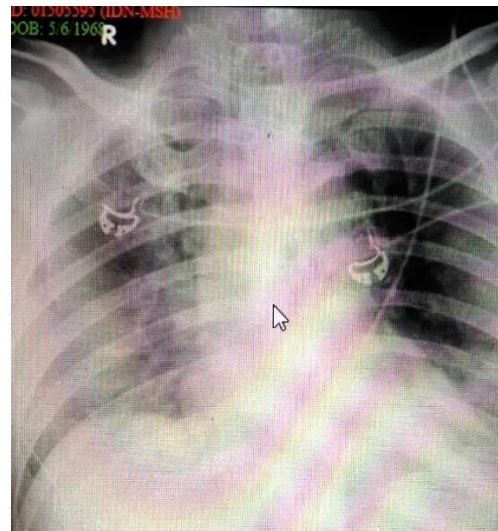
(A, B, C): Chest x-ray showing gradual improvement in lung structure
